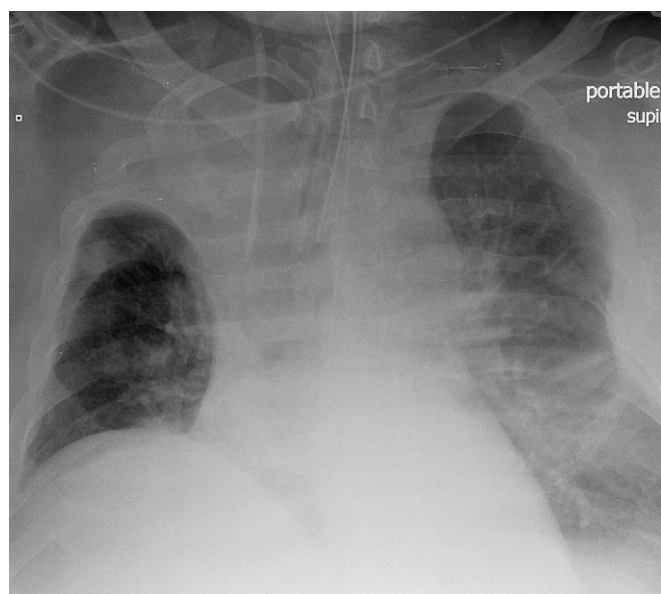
Chest radiograph of a 52-year-old man admitted to intensive care after a road traffic accident. An endotracheal tube is appropriately positioned, but there is right upper-lobe collapse. These changes persisted, and a subsequent CT scan showed a right tracheal bronchus as the cause.
